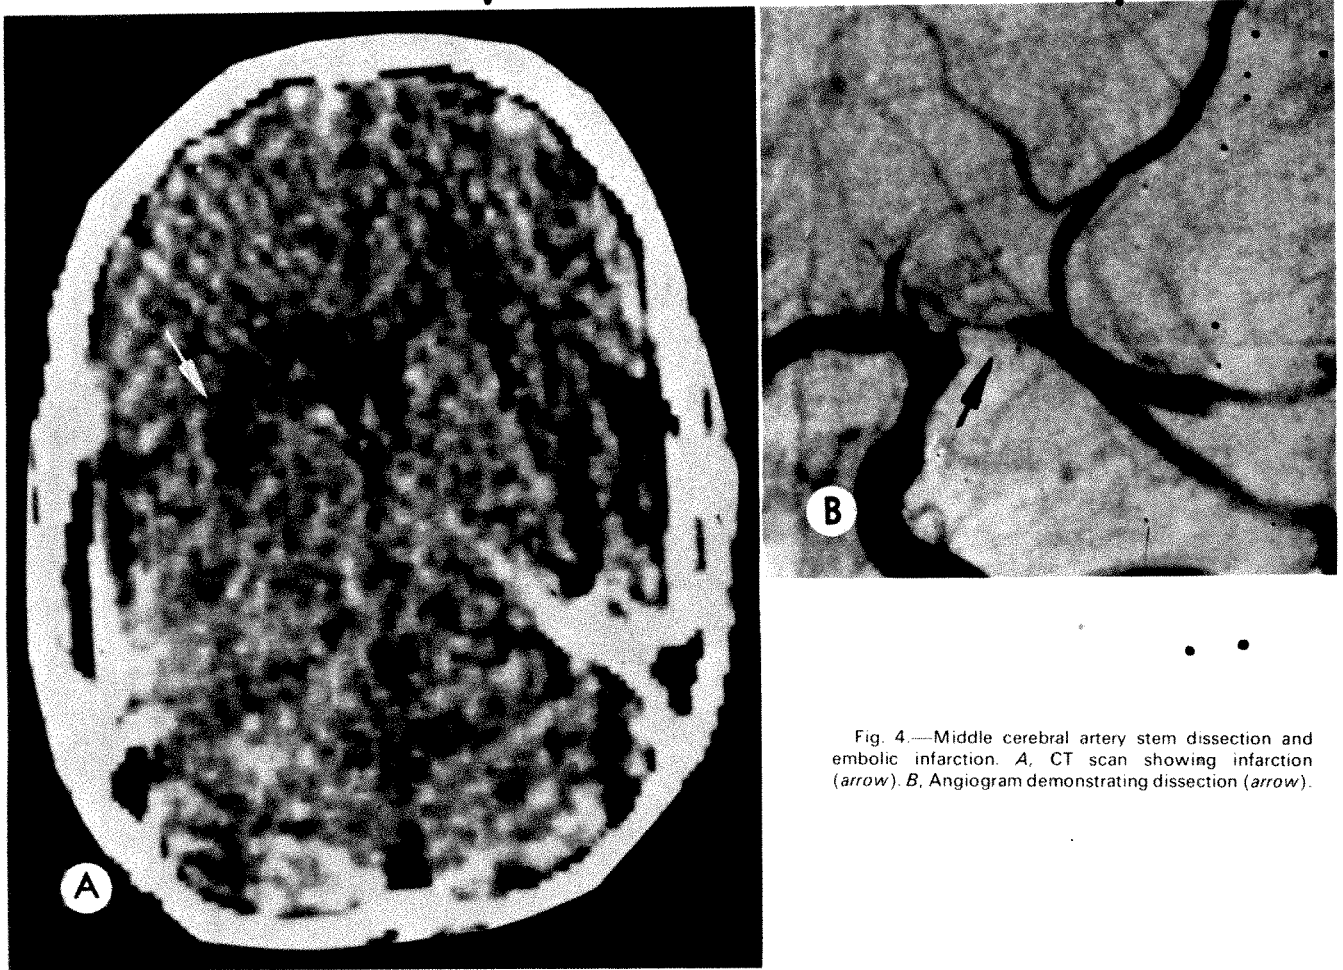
Middle cerebral artery stem dissection and embolic infarction. A, CT scan showing infarction (arrow). B, Angiogram demonstrating dissection (arrow).
